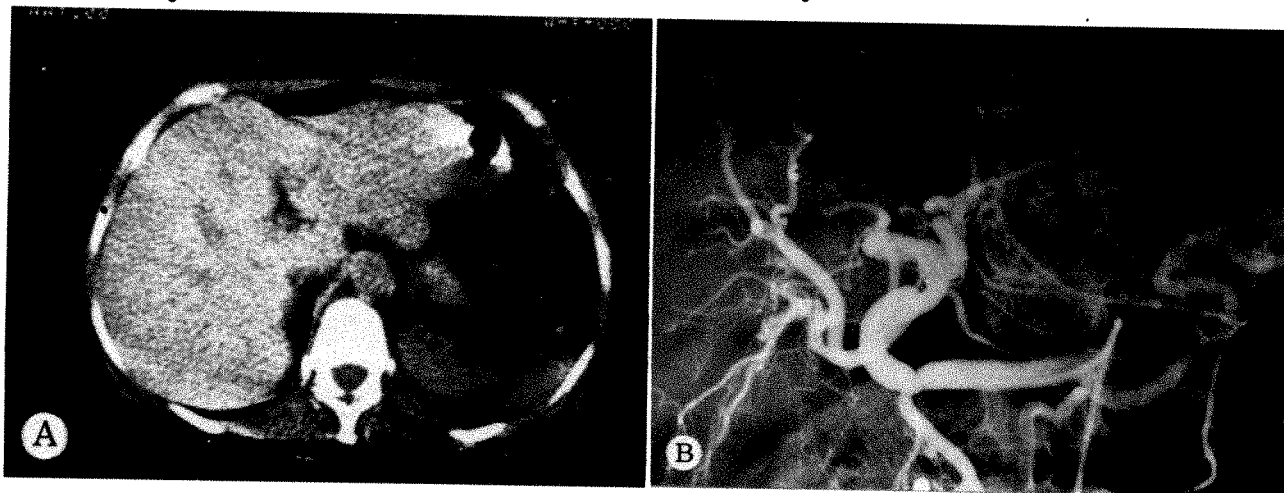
49-year-old woman with tumor of left lobe of liver discovered at bilateral salpingo-oophorectomy and hysterectomy. A, CT scan showing lobulated mass in left lobe of liver of slightly diminished density compared to adjacent normal parenchyma. Several low density areas in region of porta hepatis within normal limits. B, Hepatic arteriogram showing mass lesion in left lobe of liver with tumor vascularity. Focal nodular hyperplasia of left lobe of liver discovered at operation.
